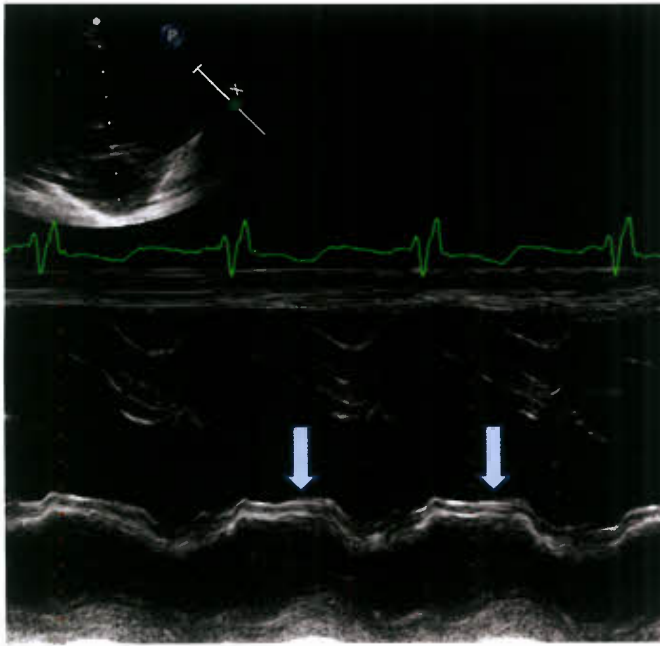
Paradoxical motion of the interventricular septum in a patient with a large atrial septal defect. M-mode obtained from a parasternal short-axis view through the dilated RV and smaller LV. The arrows show the motion of the interventricular septum in the direction of the RV in systole. This paradoxical systolic motion makes it impossible to use shortening fraction as a measure for LV systolic function in this setting.
